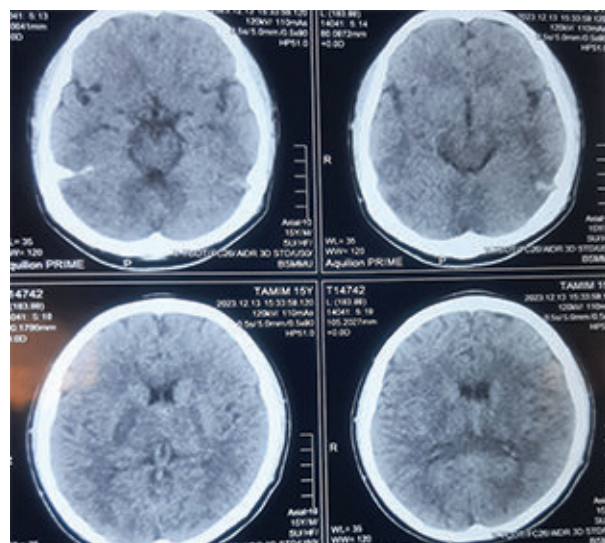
Plain multi-axial CT scan of head showing linear hyper dense lesion in left temporal region resembling dense clot sign over the left transverse sinus.
